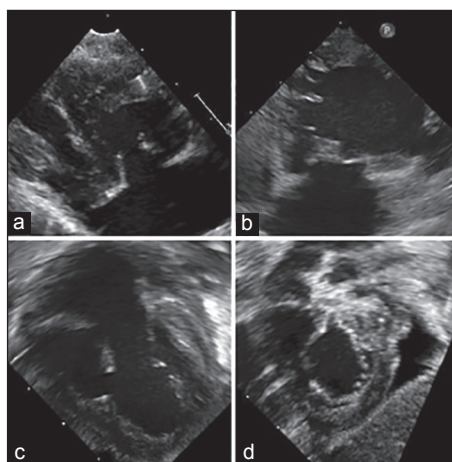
3DE interrogation of the tricuspid valve (TV) should be performed in (a) the parasternal long axis imaging plane with the sound beam directed toward the TV, (b) the parasternal short axis imaging plane at the level of the TV, (c) the apical four-chamber imaging plane, and (d) the subcostal sagittal imaging plane with the sound beam directed toward the TV
